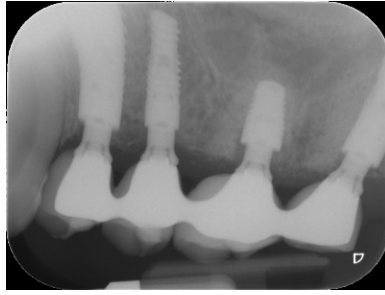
Final intraoral X-rays.*
